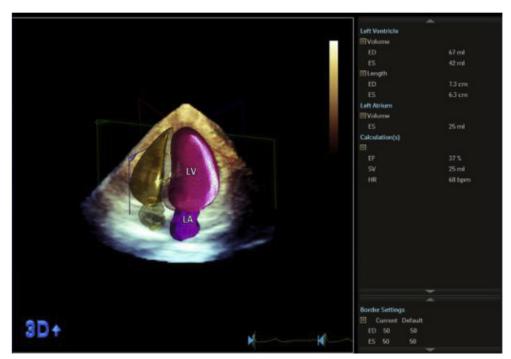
LVEF by 3D echocardiography. Three-dimensional four-chamber apical view of a 56-year-old man with HF in New York Heart Association functional class III and depressed left ventricular systolic function. Evaluation of left ventricular volumes and LVEF was done by 3D echocardiography using an automated adaptive analytics algorithm for quantification. LV end-diastolic (ED) volume was 67 mL; LV end-systolic (ES) volume was 42 mL; LVEF was 37%; left atrial end-systolic volume was 25 mL. *HR*, Heart rate; *LA*, left atrium; *LV*, left ventricle; *SV*, stroke volume.
